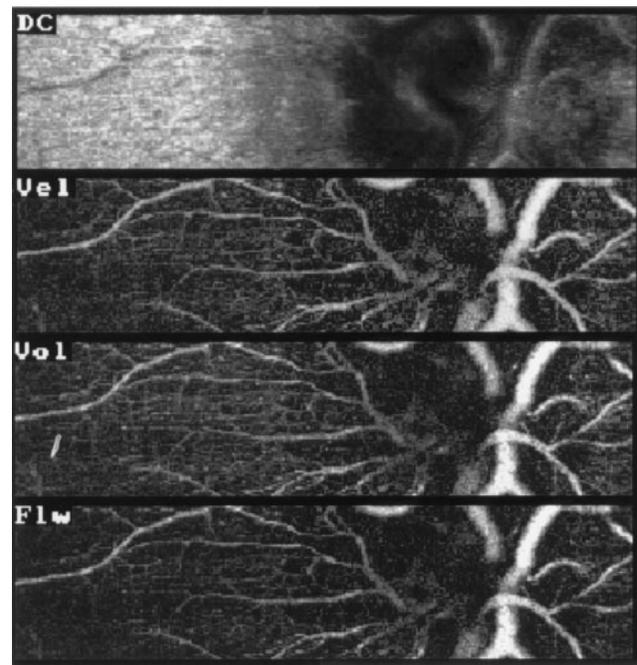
Confocal scanning laser Doppler flowmetry images obtained from a single scan of the temporal peripapillary retina of a subject in the study. (Top) Reflectivity image, akin to a funduscopy image and perfusion maps showing the (second) velocity, which is proportional to the mean Doppler shift; (third) volume, which is proportional to the concentration of particles moving through the sampling volume of tissue; and (bottom) flow, which is proportional to the blood flow through the sampling volume. The brightness of the pixels is scaled according to the respective hemodynamic values.
